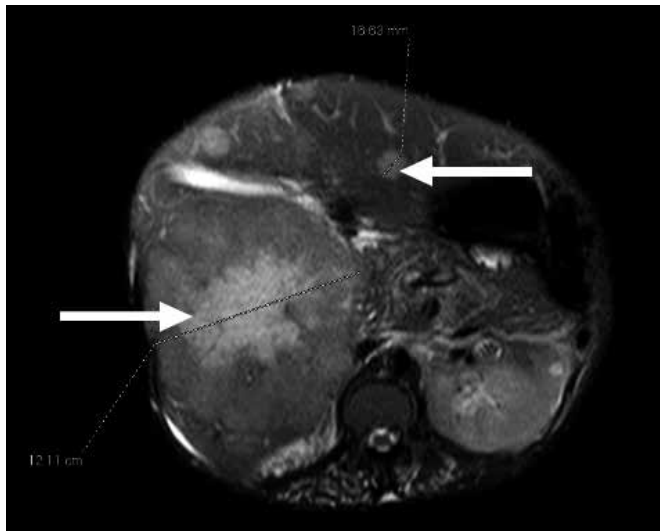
Magnetic resonance imaging of the abdomen revealing multiple hepatic masses (arrows), with the largest mass showing central necrosis.
